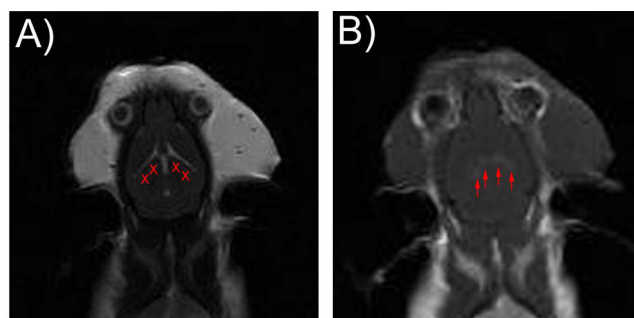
Targeting and monitoring of BBB disruption with MRI. (A) T2-weighted images (acquired on 7T Bruker Biospin 7030, Germany) were used for targeting. Four spots in the dorsal hippocampus were chosen, and each spot was marked with an x. (B) Following sonication, gadolinium contrast agent (0.2 mL/kg; Omniscan, GE Healthcare, Milwaukee, WI) was injected in the tail vein and T1-weighted images were acquired. Areas of hyperintensity are indicative of BBB disruption. Four hyperintense spots corresponding to the targeted locations are clearly visible, indicating that the sonication was successful.
